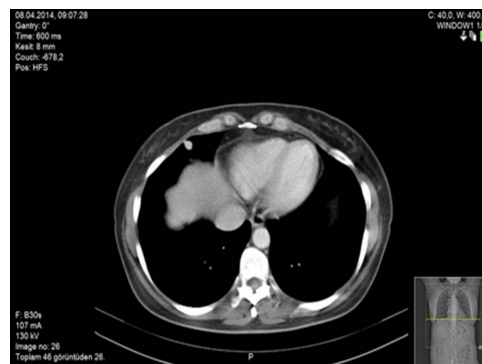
In CT, solitary nodule in the segment of the right lower lobe.
